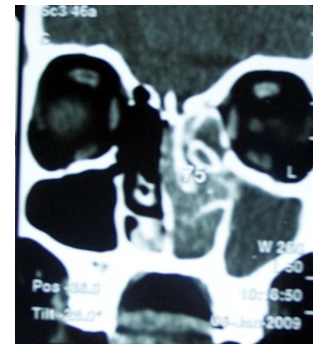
CT scan image showing the mass eroding the septum and crossing over to the opposite side
